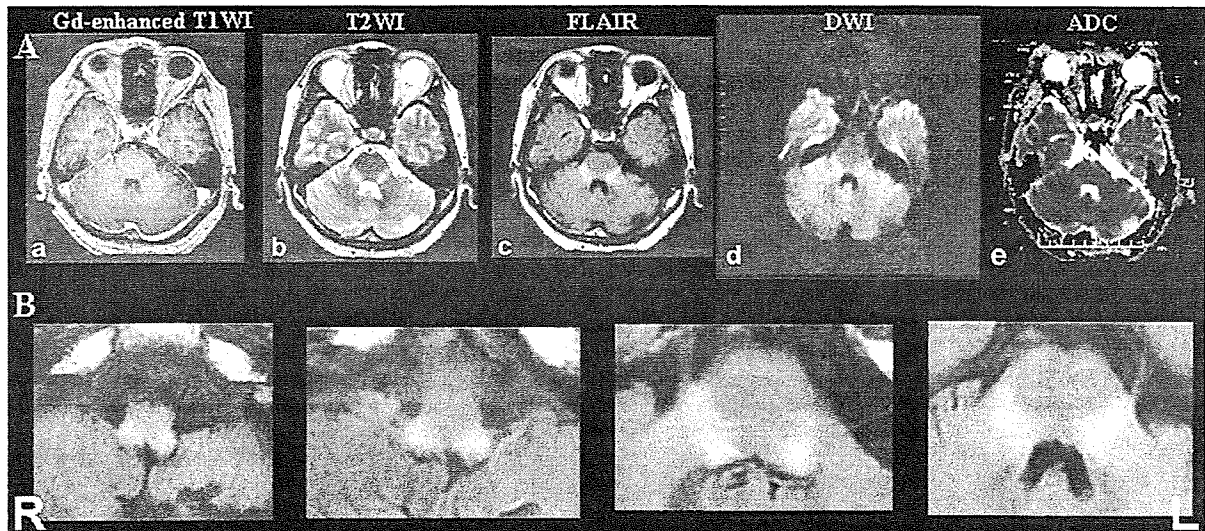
Brain MRI. (A) Panels from left to right: (a) Gd-enhanced T1-weighted (Gadolinium-enhanced T1-W1) MRI showed symmetrical low signal intensity in the bilateral pontine tegmentum and middle cerebellar peduncle, (b) T2-weighted (T2-W1), (c) fluid-attenuated inversion recovery (FLAIR) and (d) diffusion-weighted (DWI) MRI demonstrated symmetrical high signal intensity in the bilateral pontine tegmentum and middle cerebellar peduncle. In the same area, (e) apparent diffusion coefficient (ADC) imaging showed slightly high signal intensity. (B) FLAIR MRI demonstrated a high signal intensity area from the entry root of the trigeminal nerve through to the spinal tract of the trigeminal nerve in the medulla.
